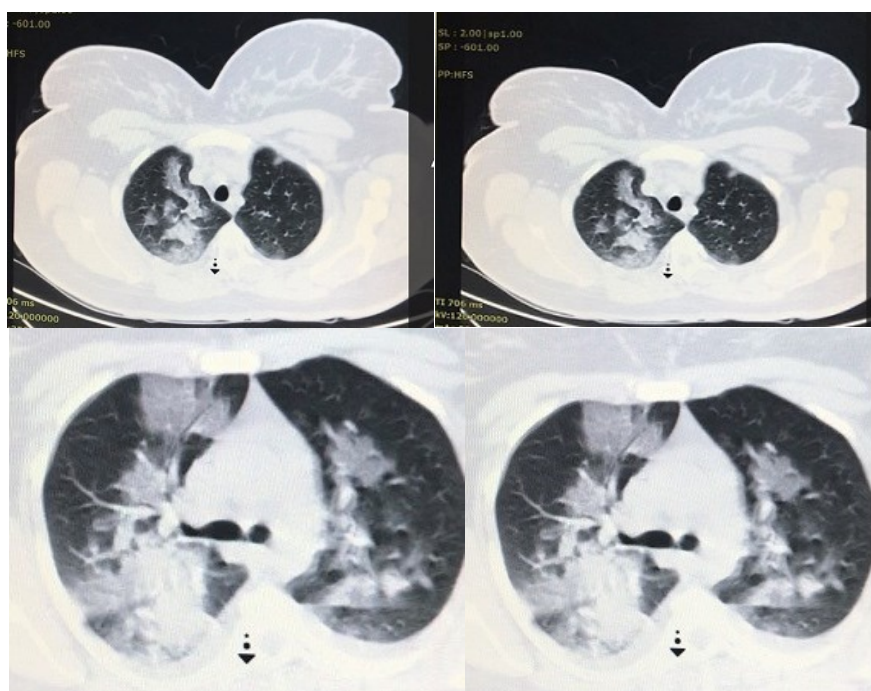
Chest computed tomography scan of patient on admission to the ICU
